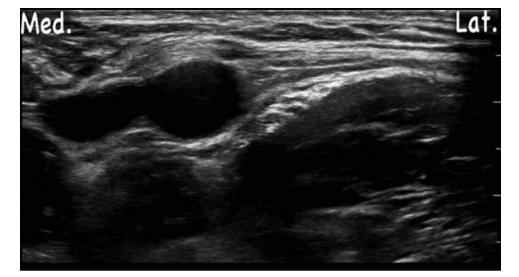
Femoral nerve under ultrasound.
